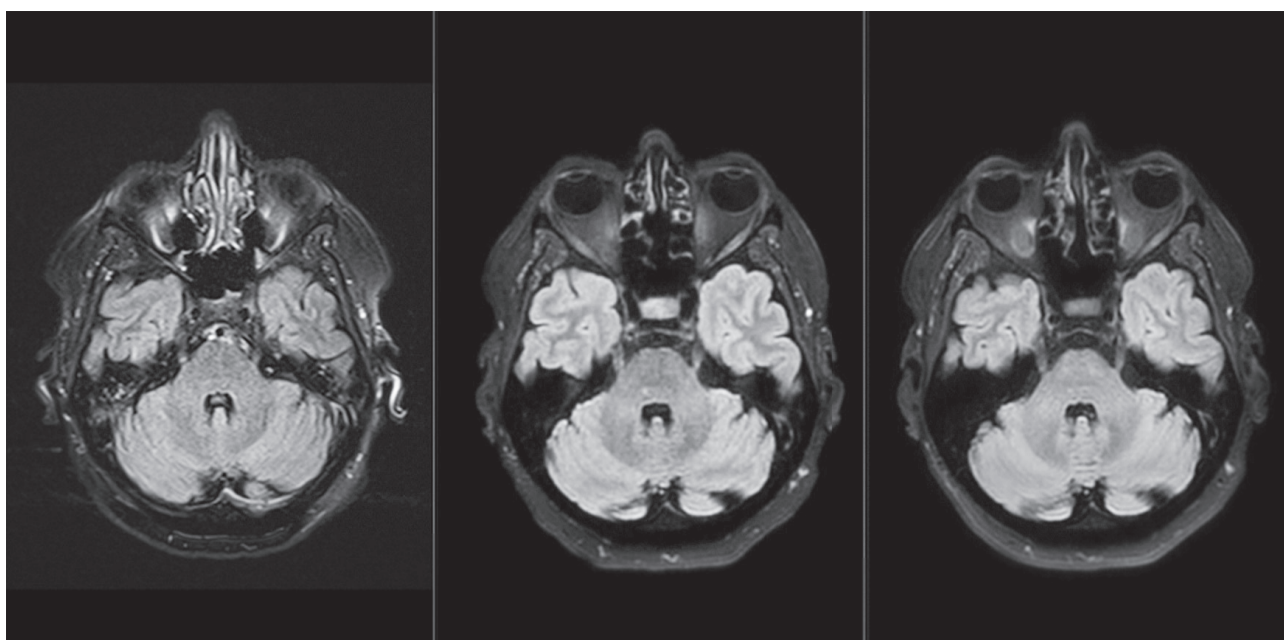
FLAIR (T2 TIRM) sequence at brainstem level
